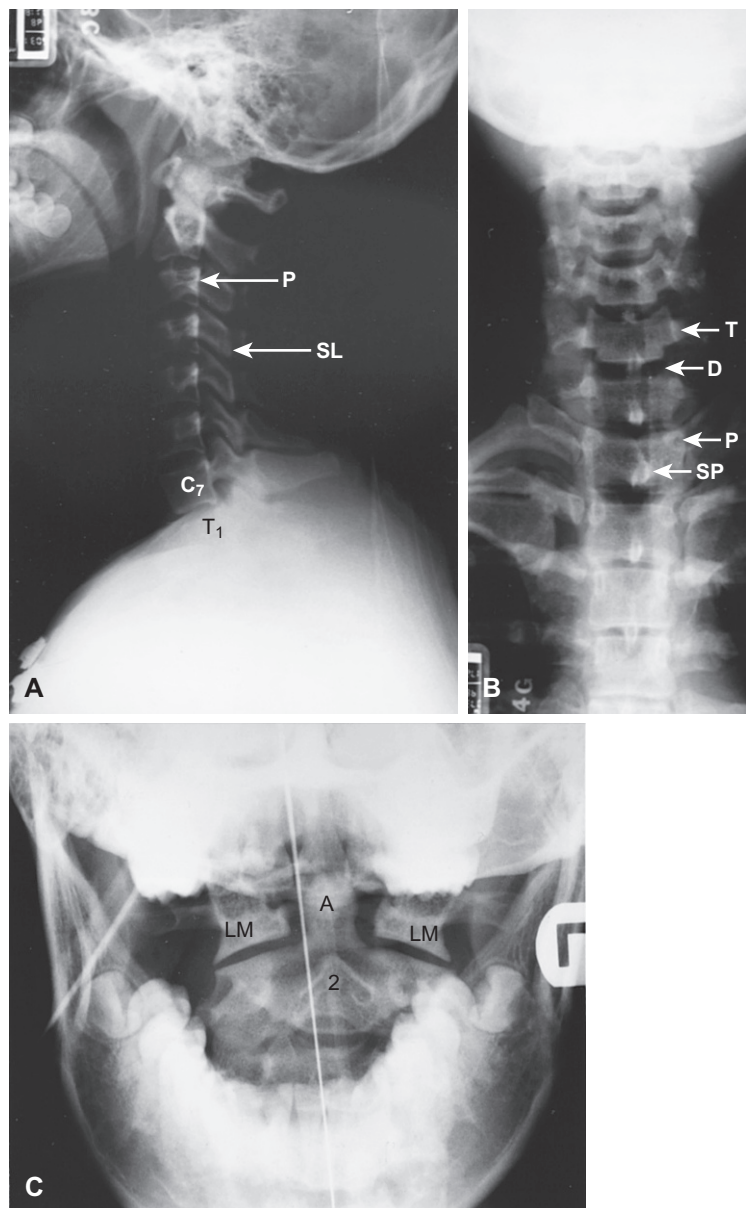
Three-view cervical spinal radiographic series. A, Lateral view of cervical spine showing alignment of posterior aspects of the vertebral bodies (P) and spinolaminar junction (SL). All seven cervical vertebrae (including C7) and the upper border of T1 should be visualized. B, Anteroposterior view showing alignment of spinous processes (SP) and vertebral bodies. Note the uniformity of disk spaces (D). Also visualized are transverse processes (T) and pedicles (P). C, Open-mouth (odontoid) view showing the odontoid (A). The odontoid is normally centered between the lateral masses (LM) of C1. The body of C2 (2) should be clearly visualized.
